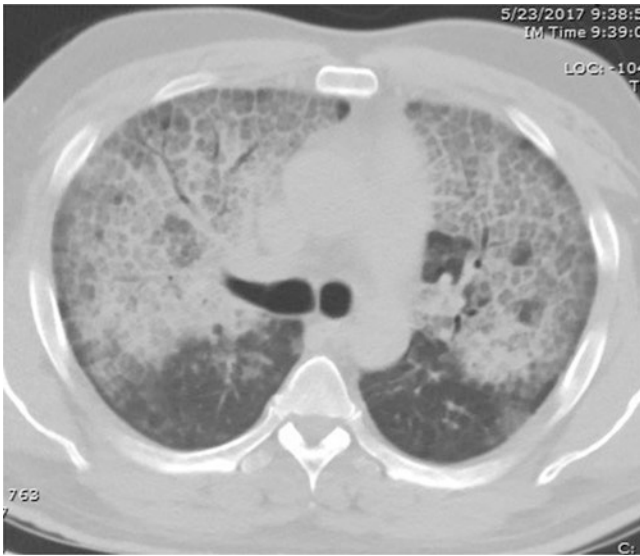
Chest CT features of PAP. PAP demonstrates bilateral ground-glass opacities and thickened inter- and intralobular septa in a “crazy paving” pattern. Pulmonary edema can also present with this pattern, especially in cases of pulmonary edema due to acute respiratory distress syndrome
